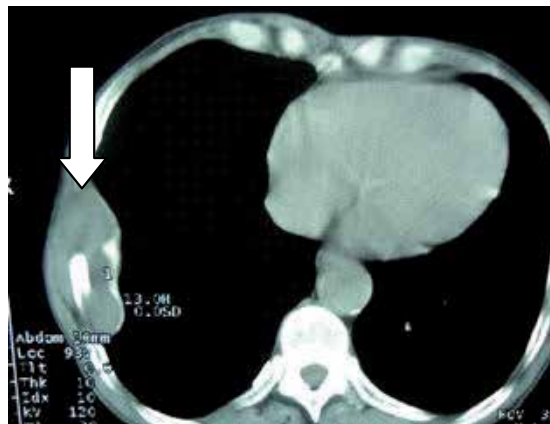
CT scan of rib hydatid cyst (arrow)
